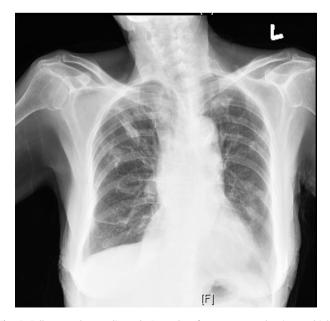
Follow-up chest radiograph 2 weeks after treatment showing multiple resolving pulmonary lesions.
